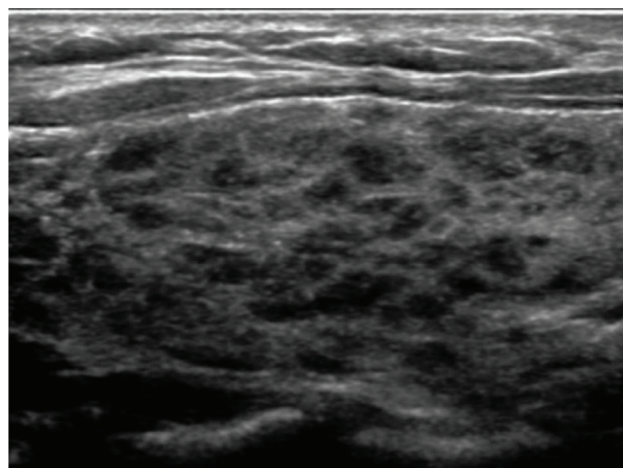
Patient N., 28 years old. Ultrasound of the thyroid gland after COVID-19 diseases. A pseudo-micronodular variant of the “honeycomb” type.
